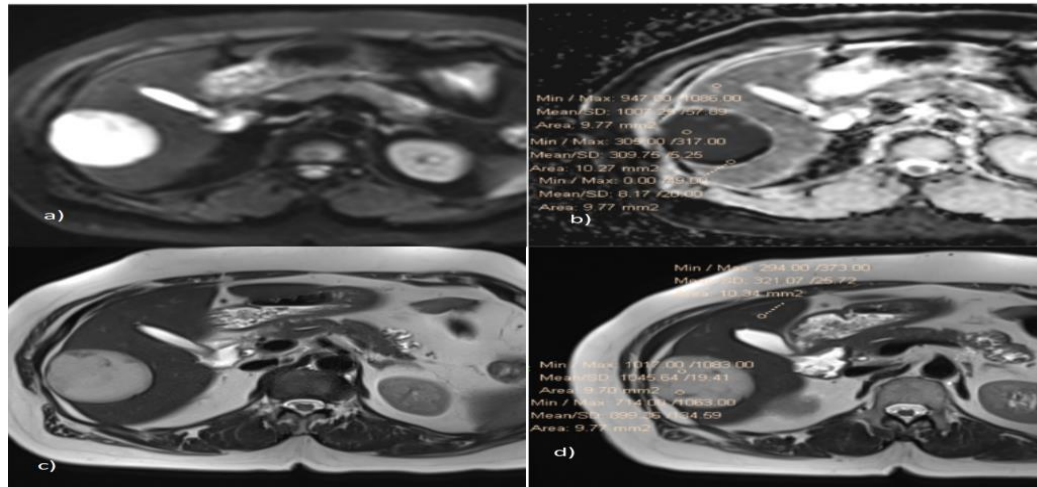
MRI abdomen showing focal liver lesion; a)&b) Axial DWI and corresponding ADC images showing heterogeneously hyperintense lesion with corresponding low ADC values in the right lobe of liver. On ADC map, it shows b value of $0.3 \times 10^{-3} \text{mm}^2/\text{s}$ c)& d) axial T2W image showing heterogeneous hyperintense signal with T2 signal of $0.7 \times 10^{-3} \text{mm}^2/\text{s}$.
